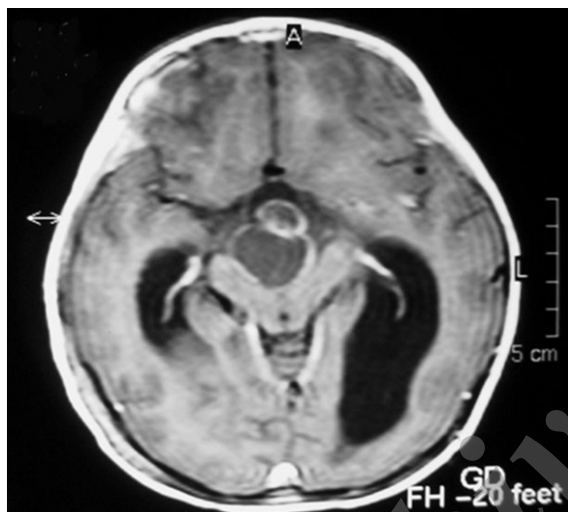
Pre-operative axial MRI after the injection of gadolinium with partial enhancement: Widening of the cerebral peduncle in the midbrain and compressing of the brain stem can be seen.
